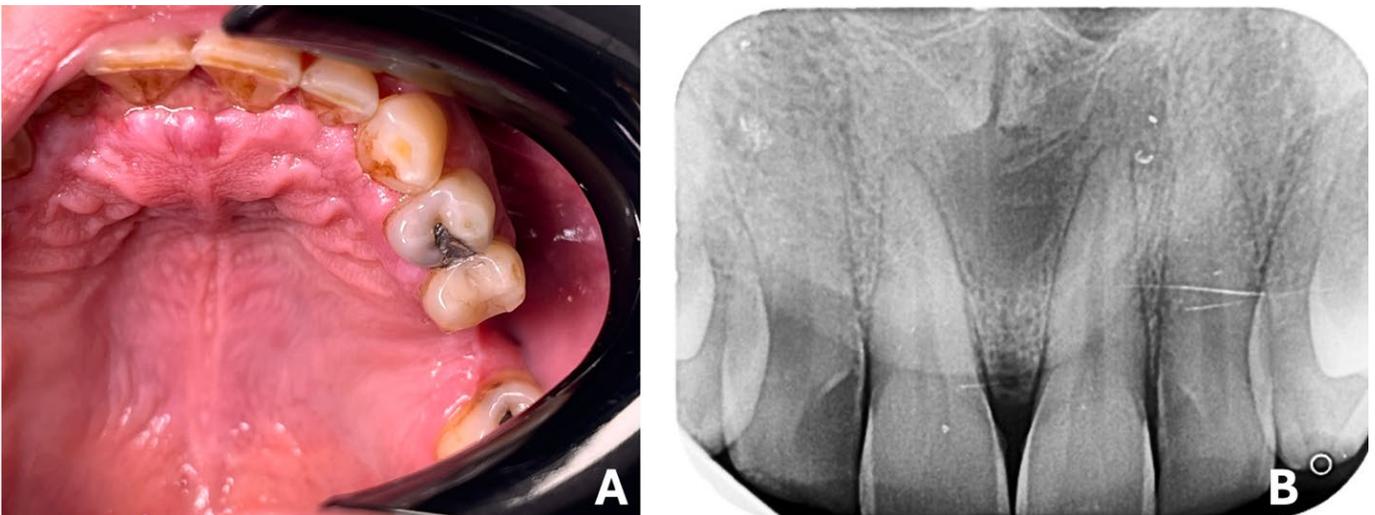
One week following surgery, (A) the oral mucosa demonstrates satisfactory healing, and (B) the periapical radiograph reveals a radiolucent area corresponding to the empty cystic cavity in the anterior region.
